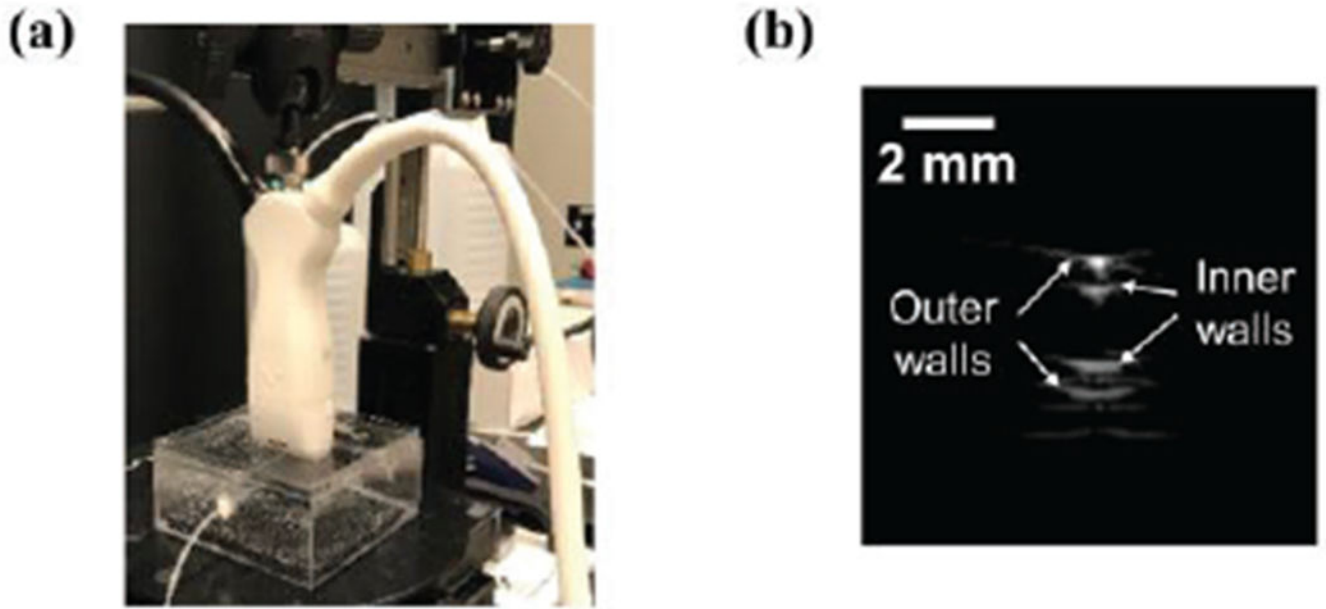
(a) Experimental setup for imaging PFHnDs and (b) an example B-scan ultrasound image of the cross-section of the tube.
